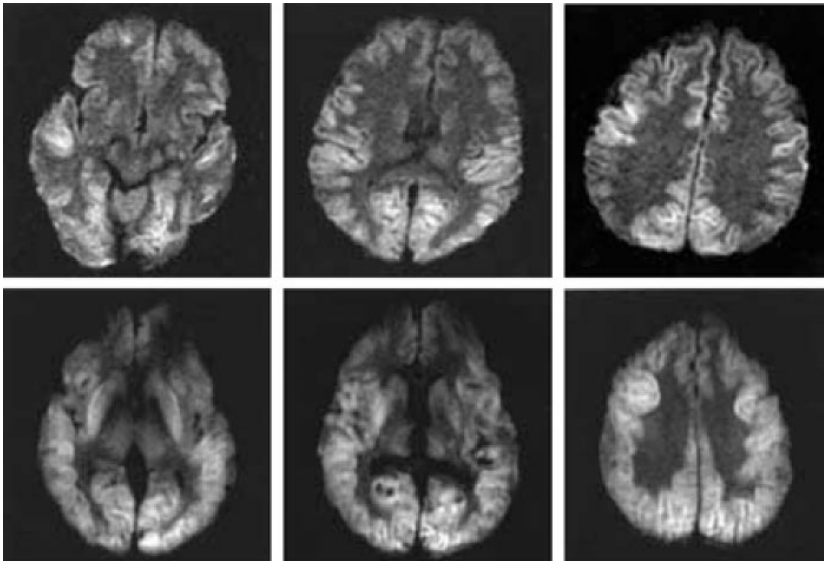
Magnetic resonance image obtained in evaluation of patient in question 2. (Reprinted with permission from Barrett KM, Freeman WD, Weindling SM, et al. Brain injury after cardiopulmonary arrest and its assessment with diffusion-weighted magnetic resonance imaging. *Mayo Clin Proc* 2007;82: 828–35.)
